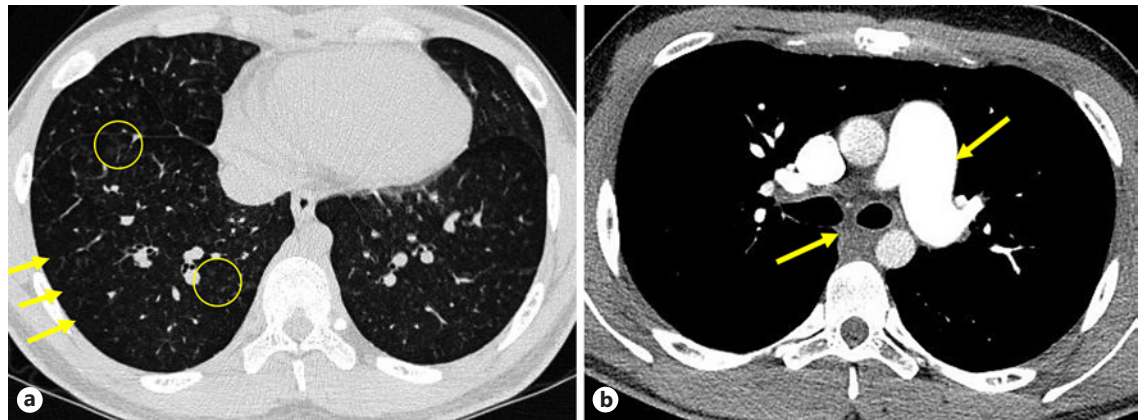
Chest computed tomography. a Diffuse ground-glass opacity nodules (yellow circles) were seen with sparing of subpleural regions in both lungs (arrows). b Mediastinal and hilar lymphadenopathy (left arrow) were noticed bilaterally. Note main pulmonary arterial dilation (right arrow). Ground-glass opacity nodules and mediastinal and hilar lymphadenopathy are observed in pulmonary capillary hemangiomatosis.
